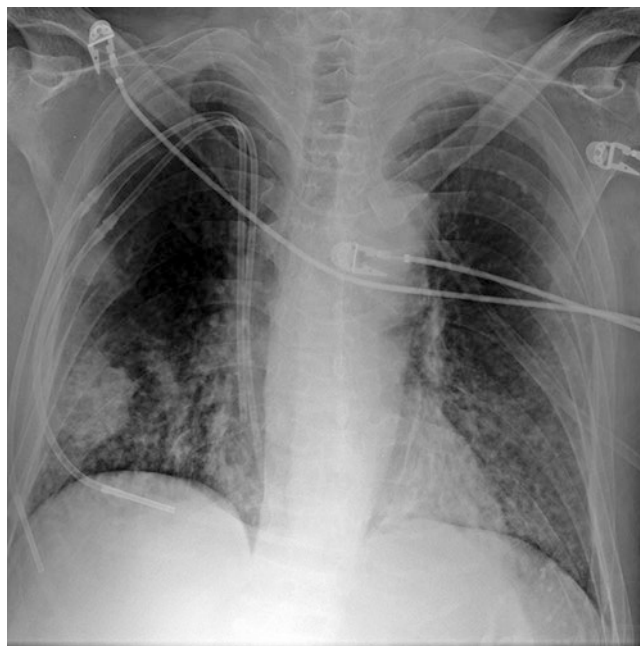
Ill-defined opacities in both lungs are apparent in this chest radiograph of a patient with metastatic pulmonary calcification
